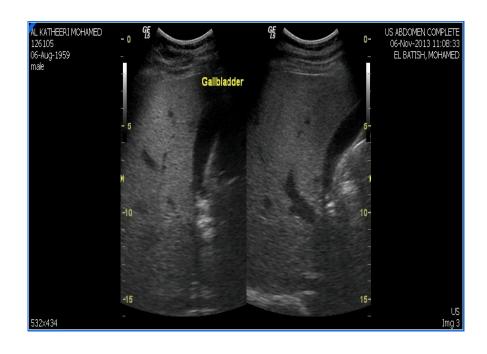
ultrasound Images of Fatty liver compared with kidney tissue
